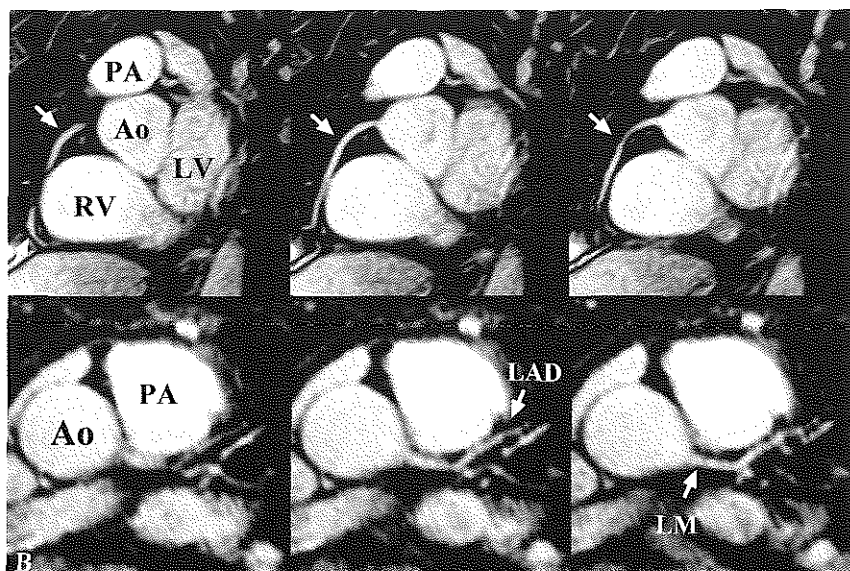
In *a* and *b*, Ao = aorta, PA = pulmonary artery. (*A*) Double-oblique, 3D, breath-hold, segmented, gradient-echo MR images (TurboFLASH, 5.3/2.3, incremental flip angle, 21 lines per segment, 110-msec acquisition window, $1.9 \times 1.25 \times 1.5$ -mm resolution with interpolation by zero filling) of the middle segment of the right coronary artery in a 45-year-old man. Three consecutive sections show the continuation of a nondiseased tortuous vessel (arrows) through the volume. LV = left ventricle, RV = right ventricle. (*B*) Transverse targeted-volume images of the left main (LM) and proximal left anterior descending (LAD) arteries in a 45-year-old woman.
